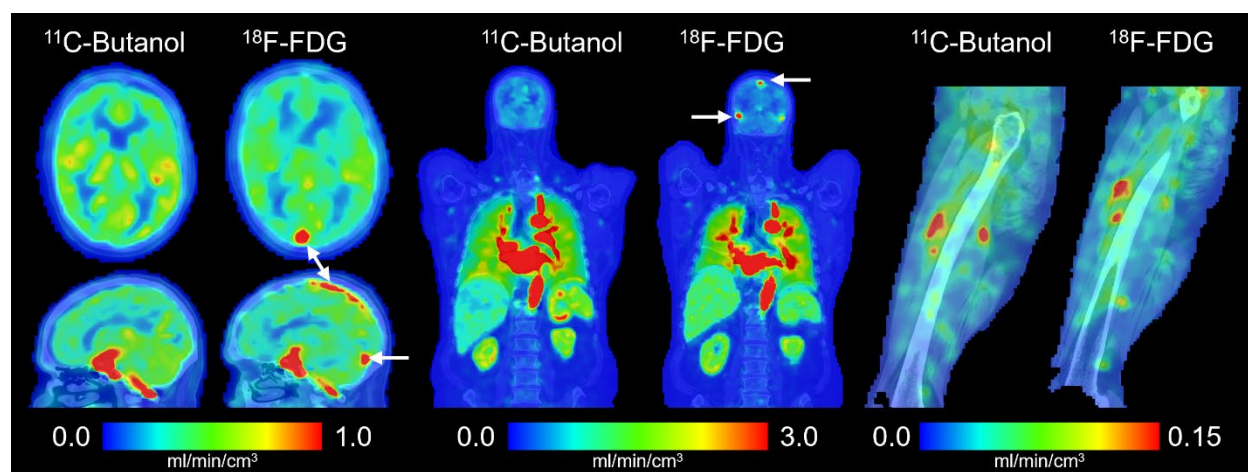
Total-body parametric imaging of blood flow with the proposed early dynamic ^{18}F -fluorodeoxyglucose (FDG) method compared against a ^{11}C -butanol flow-tracer PET reference in the same participant. The white arrows indicate the sagittal and transverse sinuses in the brain.
